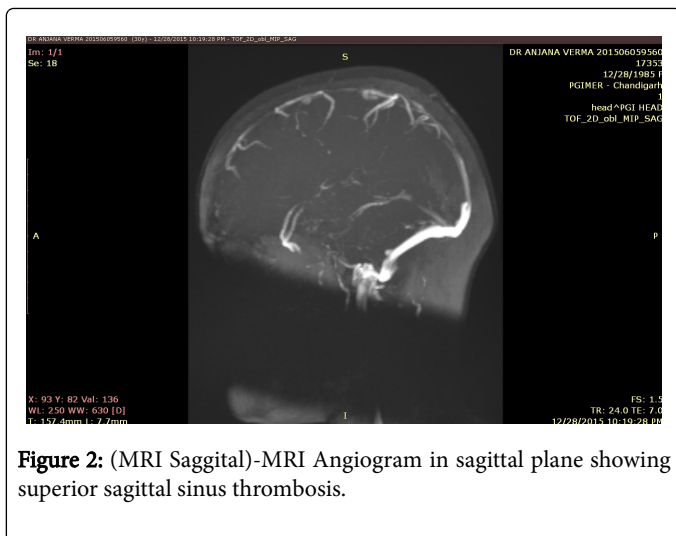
(MRI Saggital)-MRI Angiogram in saggital plane showing superior sagittal sinus thrombosis.
